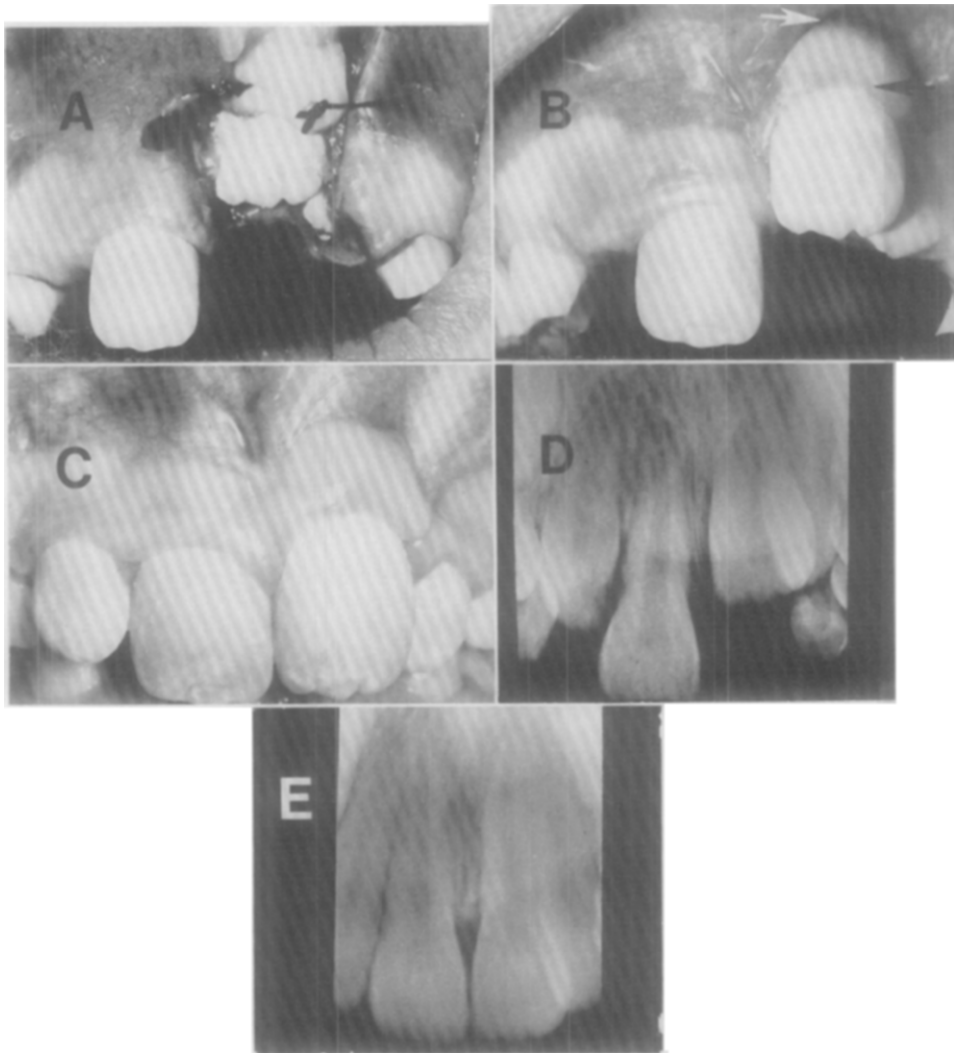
A, Surgical exposure and apical transposition of attached gingiva on delayed erupting left central incisor of an 8-year-old patient. B, One month postoperatively, note eruption that has occurred without appliances. Had the exposure been accomplished on this labially positioned central incisor without the use of a graft, alveolar mucosa would have been the marginal tissue. (Arrows indicate the width of attached gingiva.) Compare with Fig. 1, B. C, One year after completion of stage 1 treatment. Note marginal gingiva disparity, which will be corrected during the leveling stage of treatment. D, Preoperative radiograph of impacted incisor. E, Radiograph taken 1 year postoperatively.
